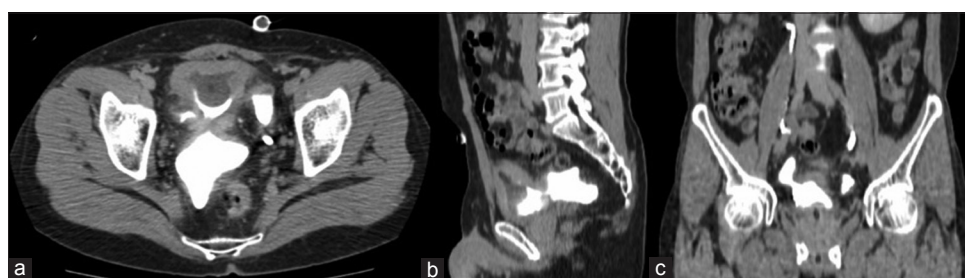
Computed tomography urogram showing (a) axial, (b) sagittal, and (c) coronal phases with 4 bladder diverticula in posterior wall
